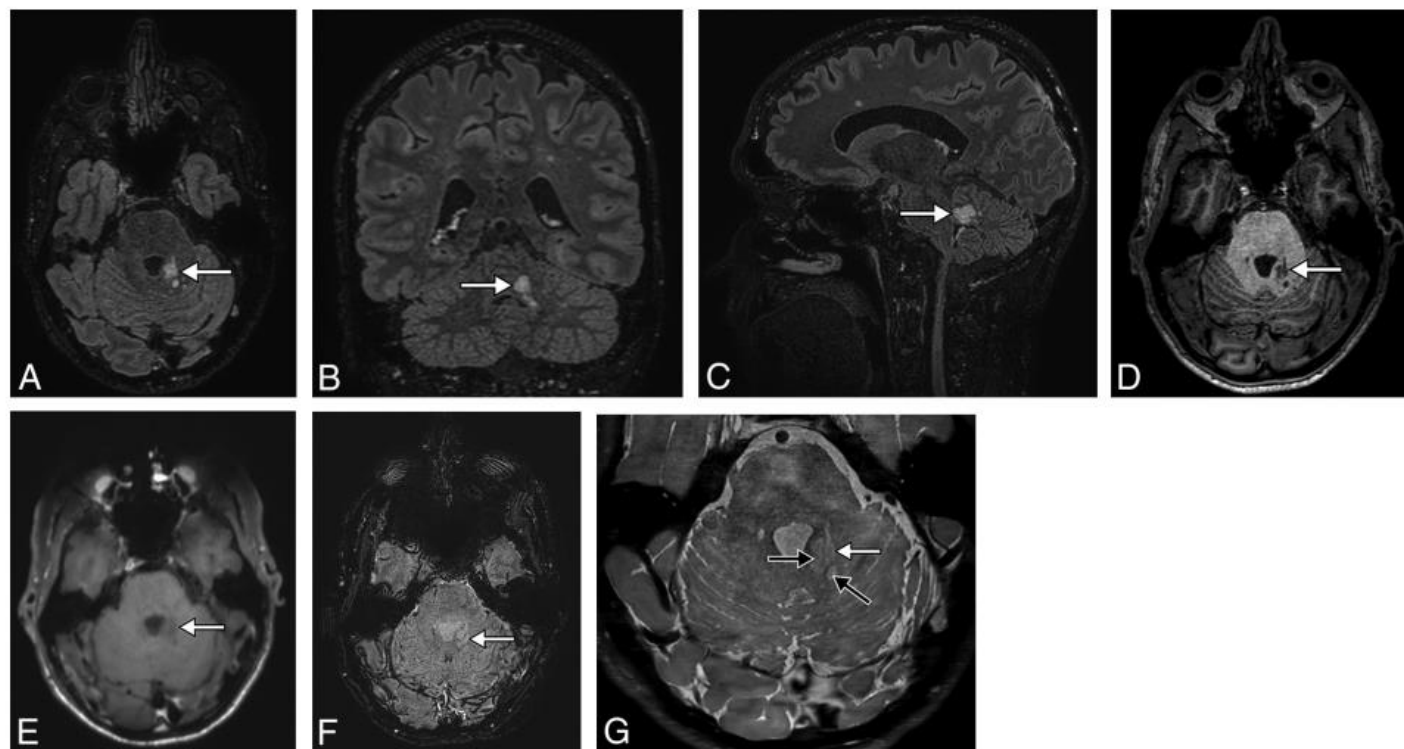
A 38-year-old man presenting with headache. 3D-T2-FLAIR reformatted in the axial (A), coronal (B), and sagittal (C) planes shows a high-signal intensity lesion (*white arrow*) of the posterior part of the left cerebellar peduncle, consisting of a coalescence of small nodules, highly suggestive of MV-PLUS. The lesion is hypointense on axial T1WI (D) and does not enhance on postcontrast T1WI (E). SWI (F) shows no blooming or intratumoral susceptibility signal. High-resolution T2WI (G) shows hypointensity in the center of hyperintense nodules (*black arrows*), consistent with a central dot sign. Note the small mass effect and distortion of the lateral margin of the fourth ventricle.
